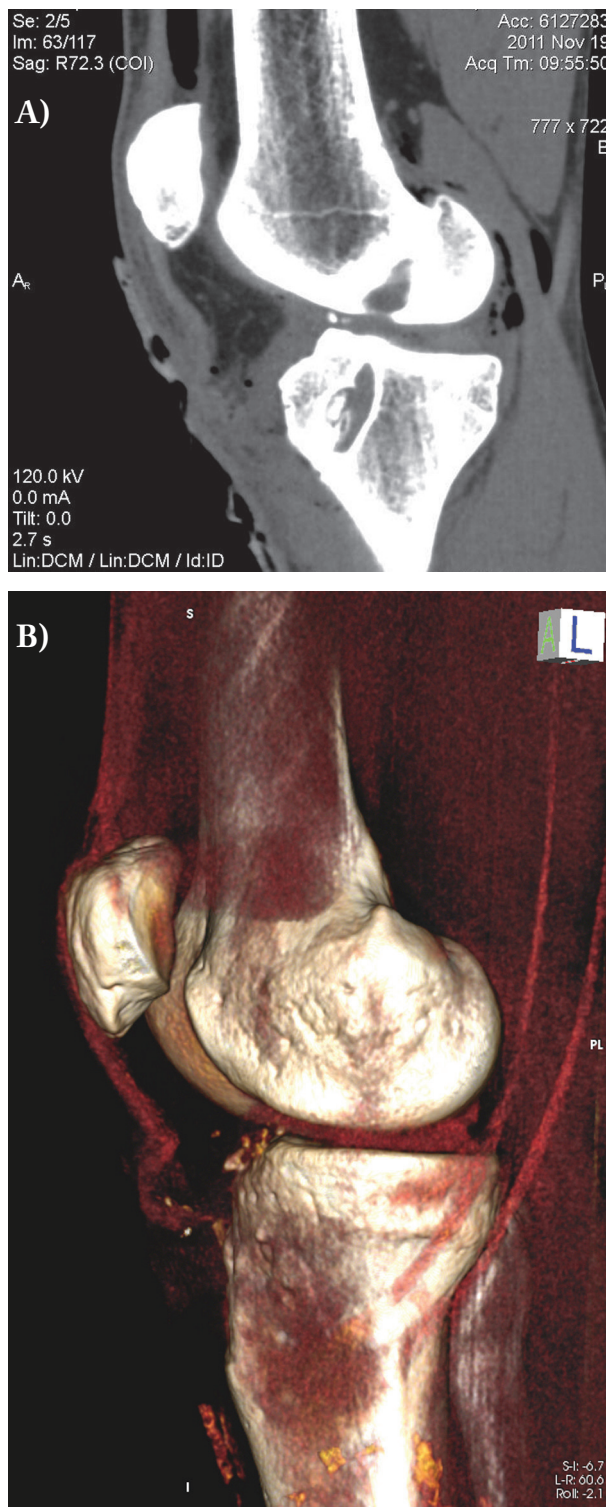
Urgent CT-scan, sagittal image [A] and 3D reconstruction [B], demonstrating patellar tendon avulsion from the tibial tuberosity
